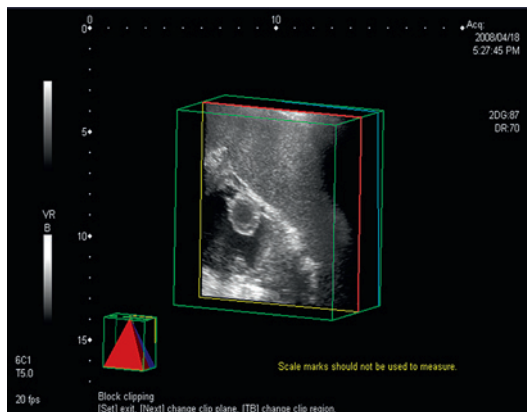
Three-dimensional sonogram.
